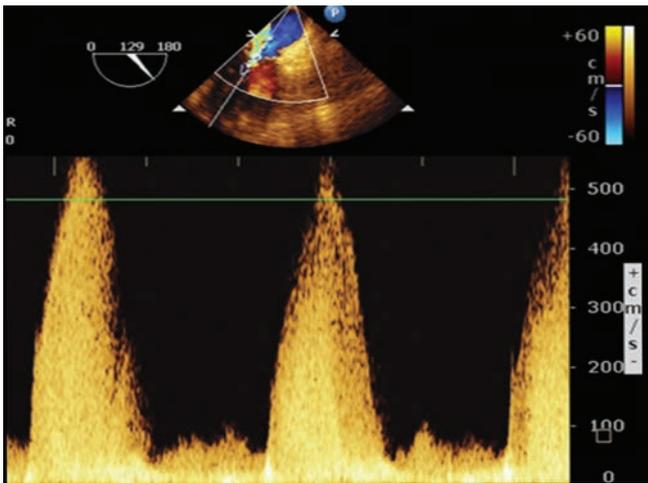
TEE Continuous wave Doppler. Shows mitral regurgitation.
